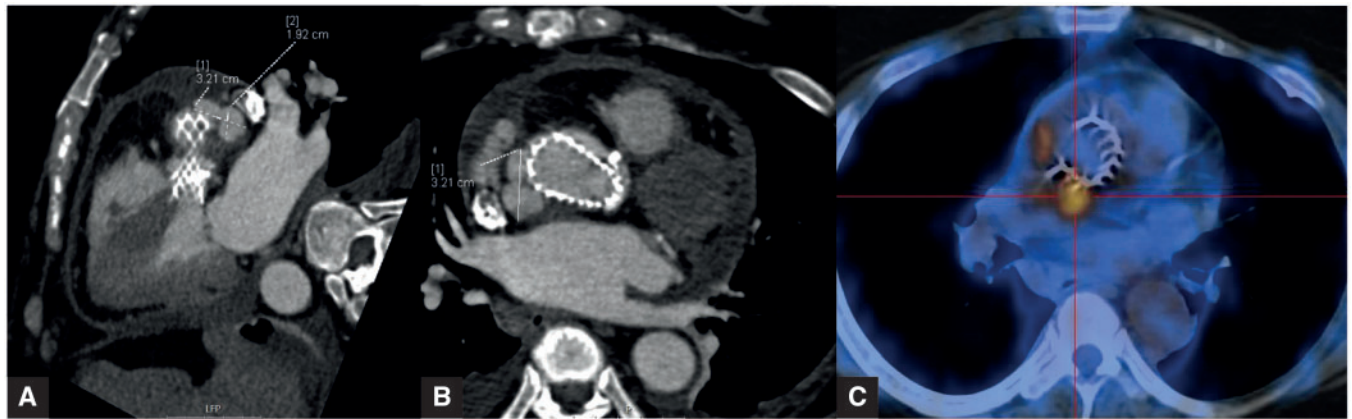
(A, B) Oblique and axial planes of the thoracic computed tomography angiogram revealing a protrusion from the aortic wall continuous with the vessel lumen, adjacent to the superior border of the prosthesis. (C) Positron emission tomography summary graphic showing avid fluorodeoxyglucose uptake on the topography of the pseudoaneurysm.
